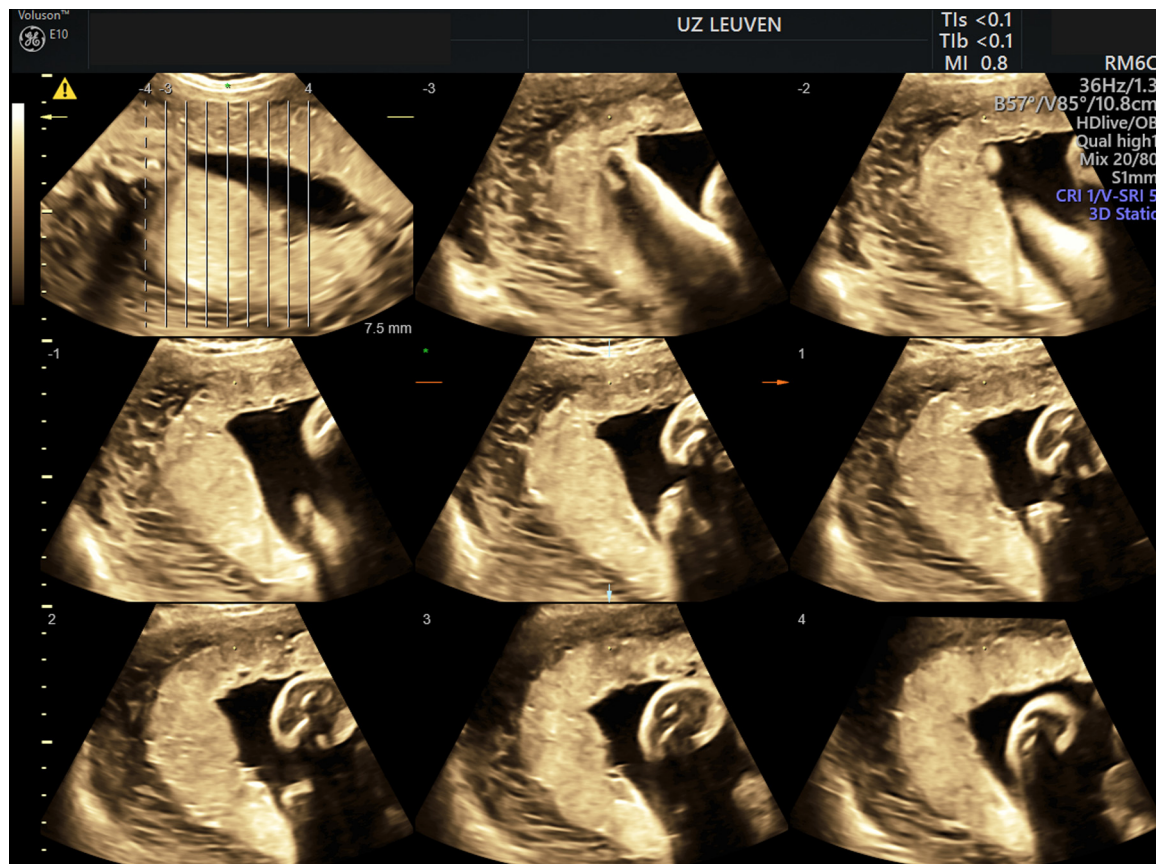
Tomographic ultrasound imaging (TUI) – volume computer aided diagnosis (VCAD) ultrasound image at 32 weeks and 5 days.
